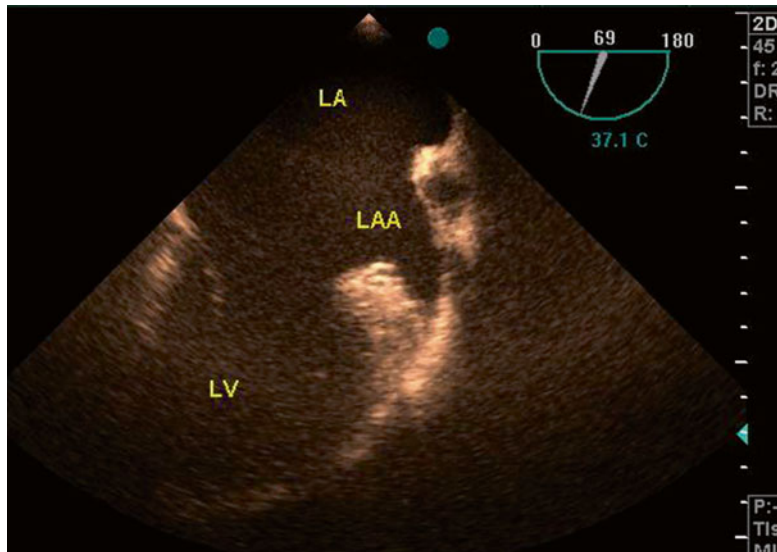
Left atrial appendage anatomy in transesophageal echocardiography as a fingerlike structure containing small pectinate muscles. *LA* left atrium, *LAA* left atrium appendage, *LV* left ventricle
